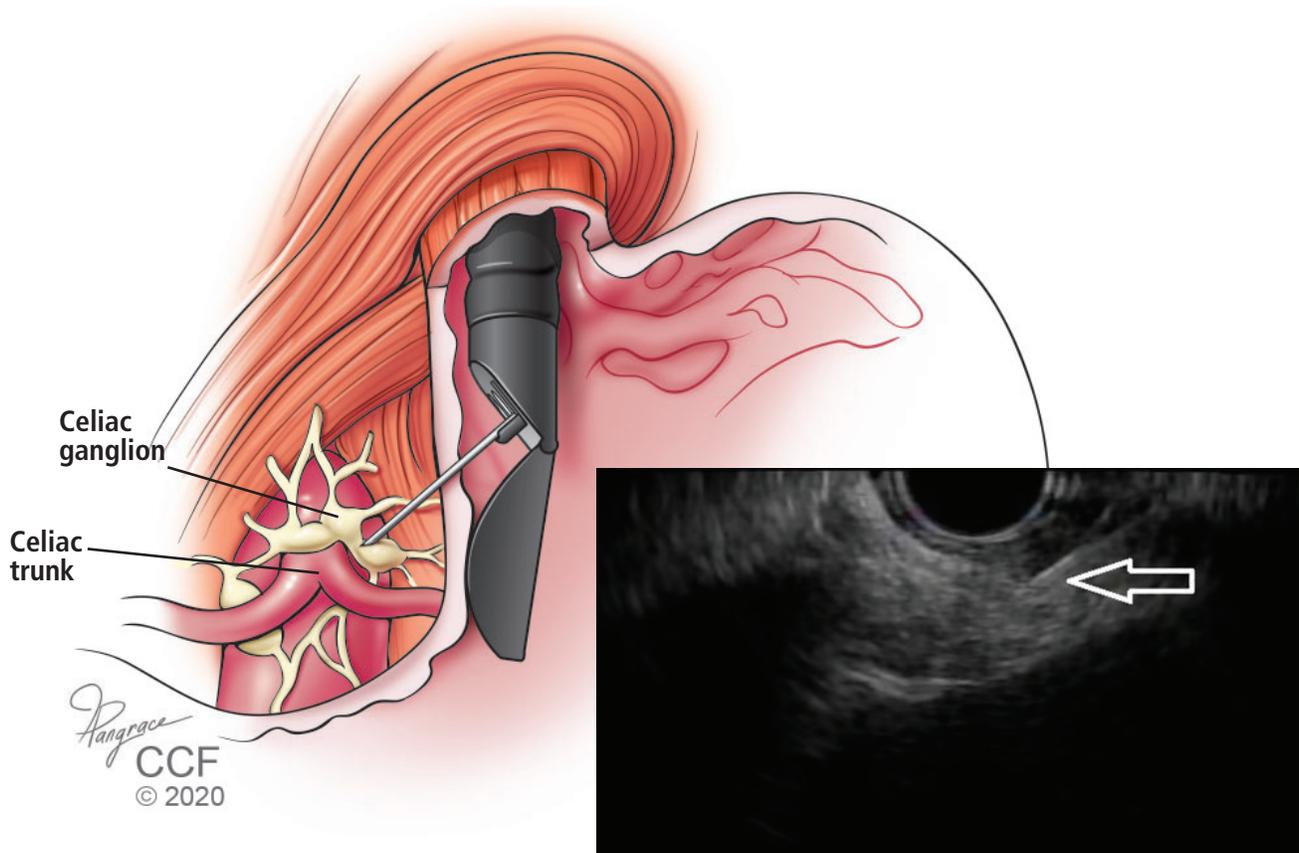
Control of chronic abdominal pain with first-line medications in patients with chronic pancreatitis or intra-abdominal malignancy may be inadequate or fraught with adverse effects. One alternative is endoscopic ultrasonography-guided fine-needle (EUS) celiac plexus block, performed under echoendoscopic guidance with passage of an injection needle. This procedure has been shown to be safe, is technically easy to perform, and is a safe alternative to percutaneous block guided by computed tomography. The arrow shows the EUS-guided placement of the needle.
